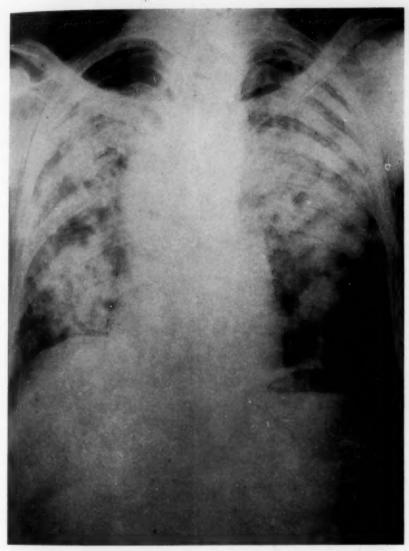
Case 1. Chest roentgenogram shows deviation of the mediastinum and trachea to the right, and a diffuse, mottled infiltrate extending peripherally from the central lung fields.
